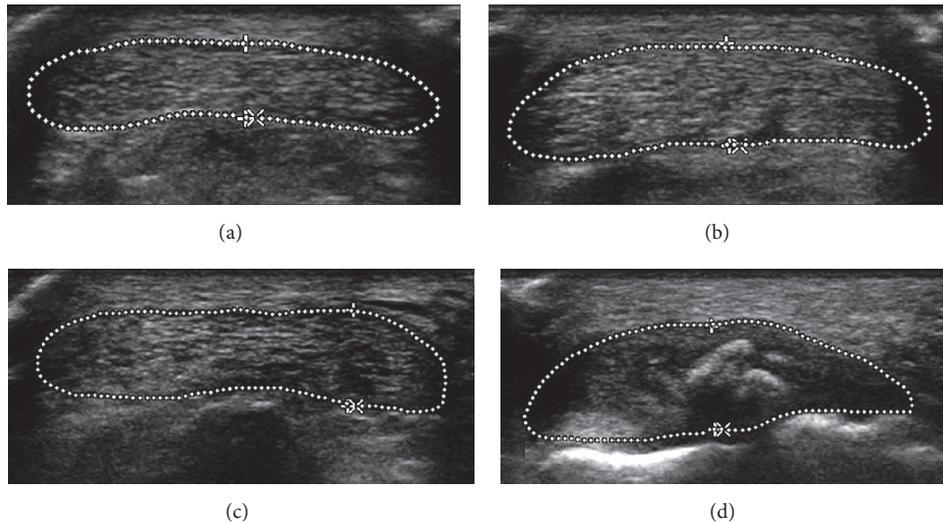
Transverse sonograms show 4-grade scale of tendon structure (outline of Achilles tendon traced by dotted line). (a) Grade 0—normal structure (homogenous echogenicity). (b) Grade 1—light structural changes (discrete hypoechoic areas). (c) Grade 2—moderate structural changes (some well-defined hypoechoic areas). (d) Grade 3—severe structural changes (extended hypoechoic areas).
